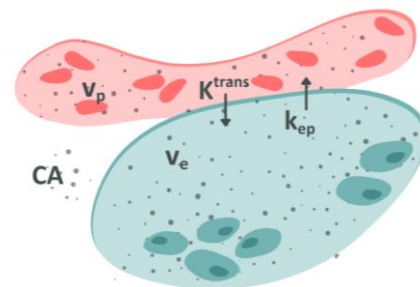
Visual representation of quantitative parameters in dynamic contrast-enhanced magnetic resonance imaging. CA: contrast agent
